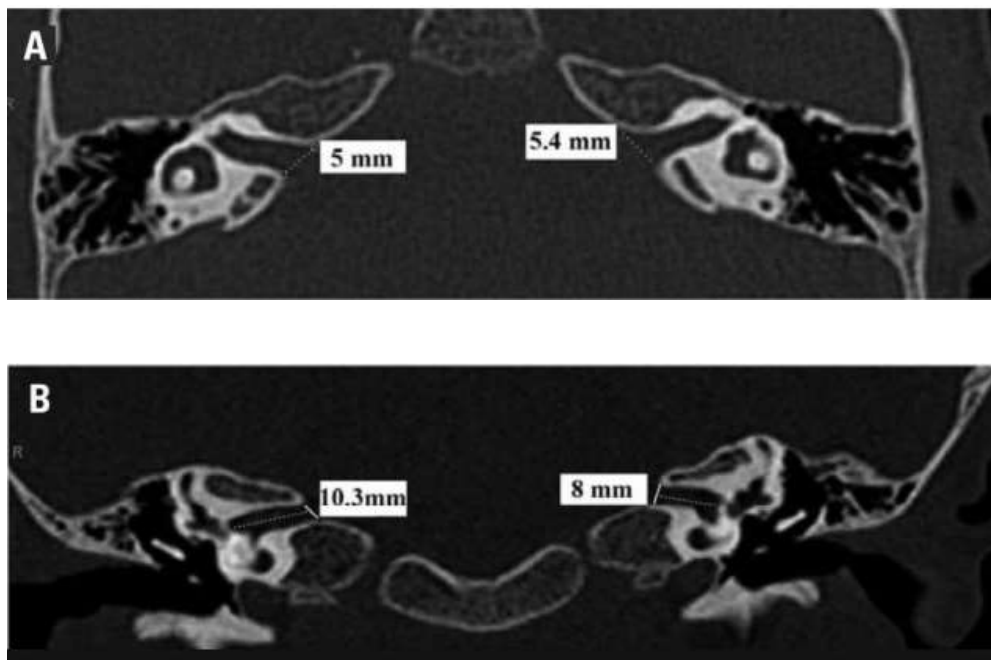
A. Axial multislice computed tomography (MSCT) slice of the temporal bones with normal IAC showing the anteroposterior diameter of the right and left canals; B. Coronal MSCT slice of the same temporal bones showing the length of the IAC of the right and left canals (El Sadik & Shaaban, 2017).
